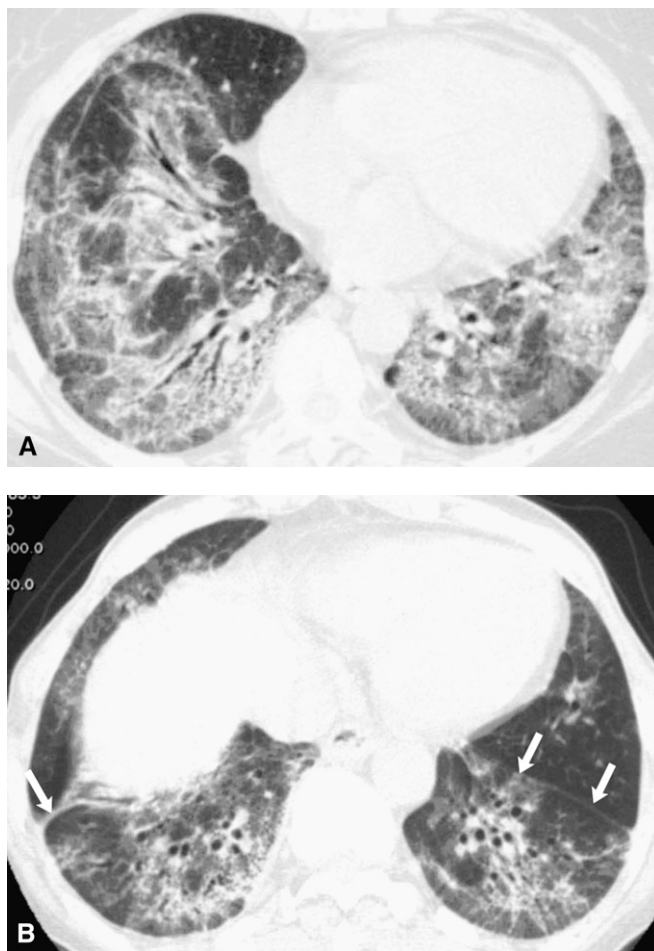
High-resolution computed tomography (HRCT) images in nonspecific interstitial pneumonia (NSIP). (A) HRCT through the lower lungs in a patient with NSIP shows confluent ground-glass/reticular abnormality and mild traction bronchiectasis. The abnormality extends along bronchovascular bundles in the right lower lobe, and spares the posterior subpleural lung. (B) HRCT through the lower lungs in a patient with NSIP shows confluent reticular abnormality and marked traction bronchiectasis. The abnormality extends along bronchovascular bundles in both lower lobes, and spares the posterior subpleural lung. There is posterior displacement of the interlobar fissures (arrows), indicating lobar volume loss.
